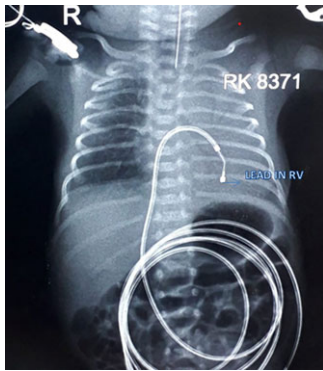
Chest X-ray demonstrating the pacing via umbilical vein with lead placed in the right ventricle.
